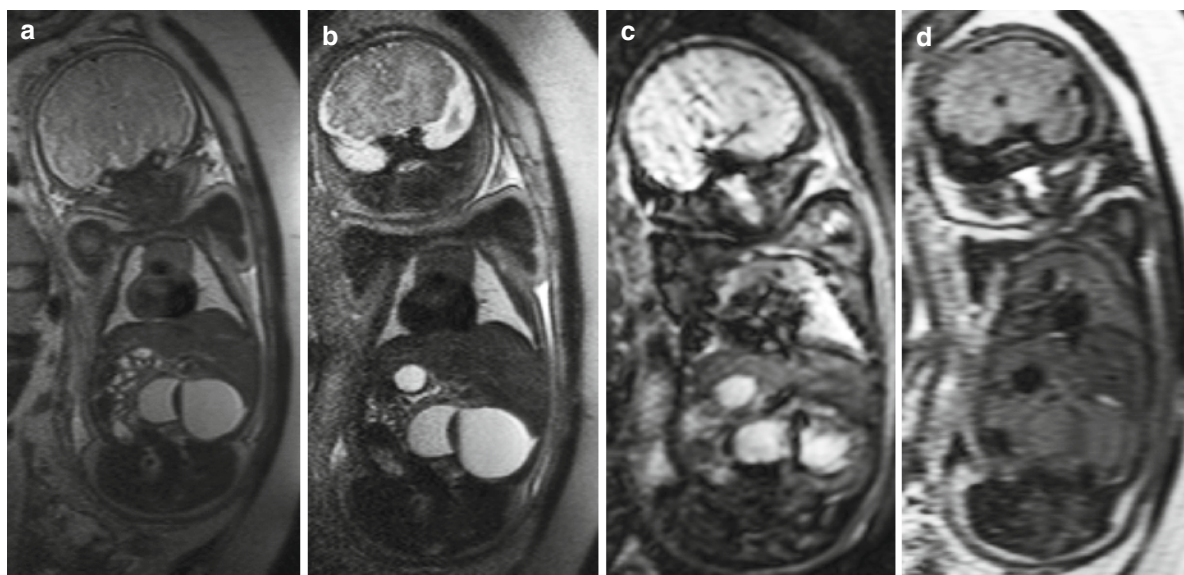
Ovarian cysts. Coronal T2-weighted image (a, b), EPI (c), and T1 FLAIR (d) images show hemorrhage into an ovarian cyst. Notice the fluid level (a–c) and the bright signals compared to the content of the stomach (d)
